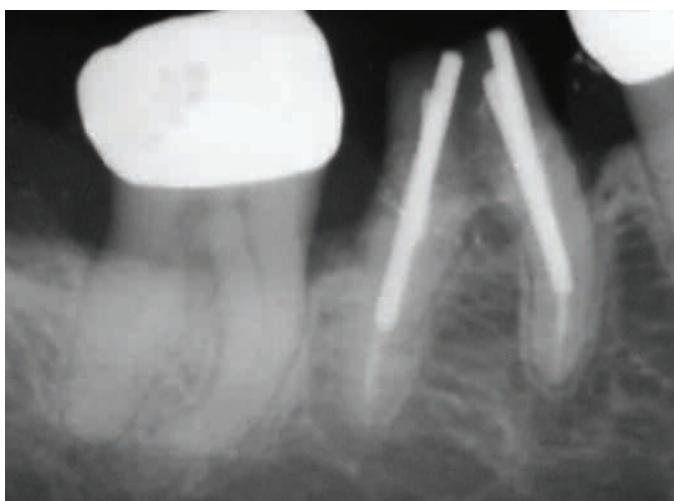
1982 radiograph. Cement washout of old crown and root caries resulted in loss of all coronal dentin.
